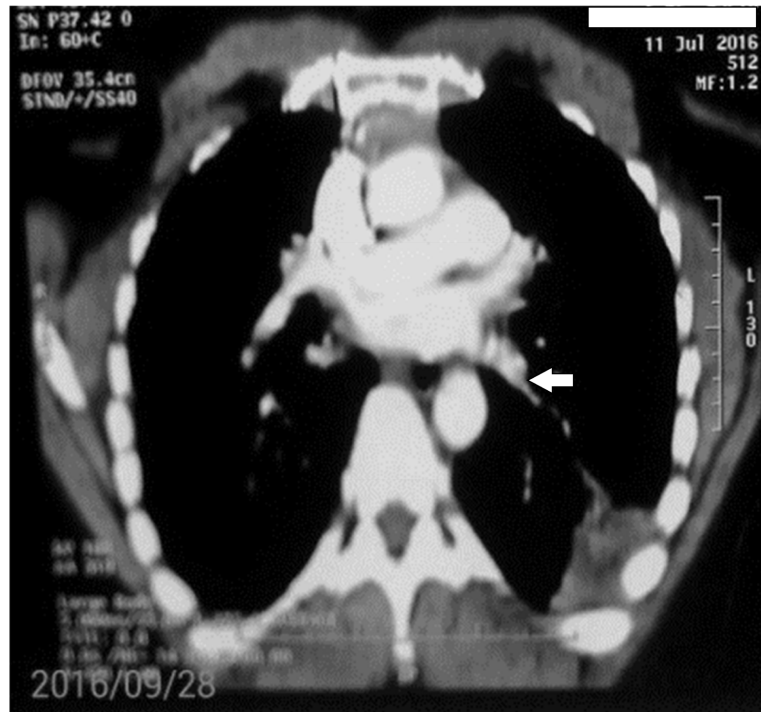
Contrast enhanced coronal HRCT image showing pleural based wedge-shaped opacity with a rounded filling defect (arrow) the distal aspect of the left descending pulmonary artery.
